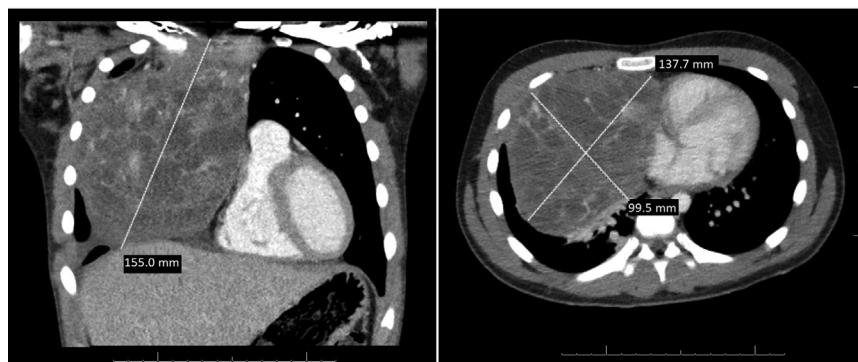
Tumor size is shown in axial and coronal planes on contrast-enhanced computed tomography.
